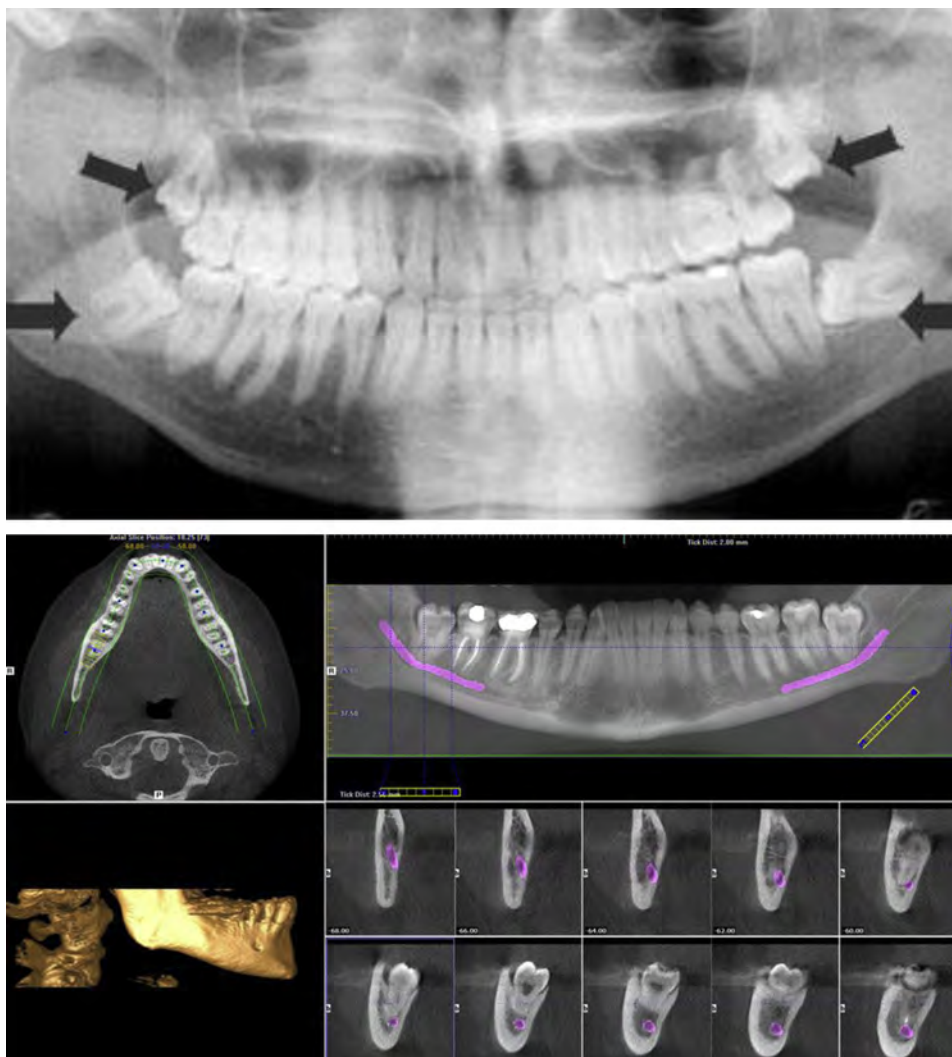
(Upper) 2-D orthopantomogram demonstrating wisdom teeth. (Lower) 3-D CBCT with particular emphasis on the inferior alveolar canal and its relationship to the third molar mandibular teeth. (Courtesy of Queensland X-Ray, Queensland, Australia; with permission.)
